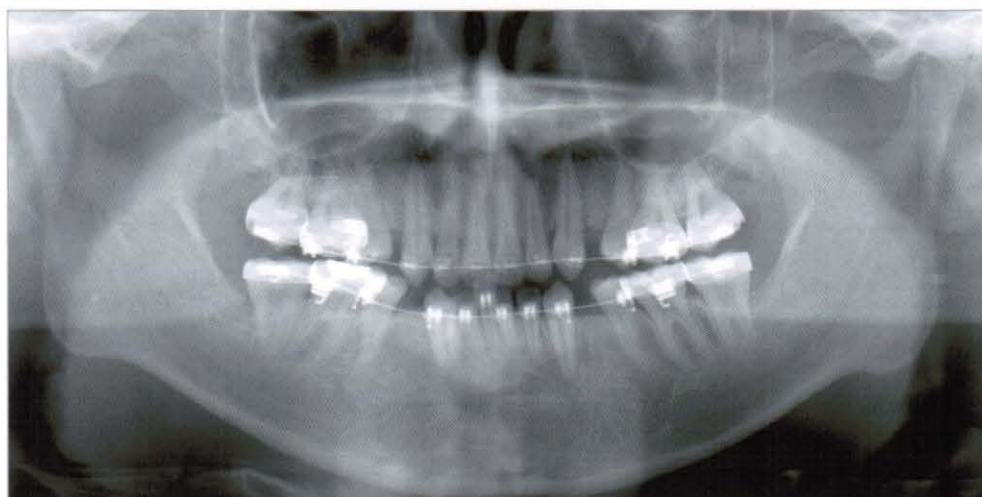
Panoramic radiograph after leveling (up to 016×022° NiTi)
